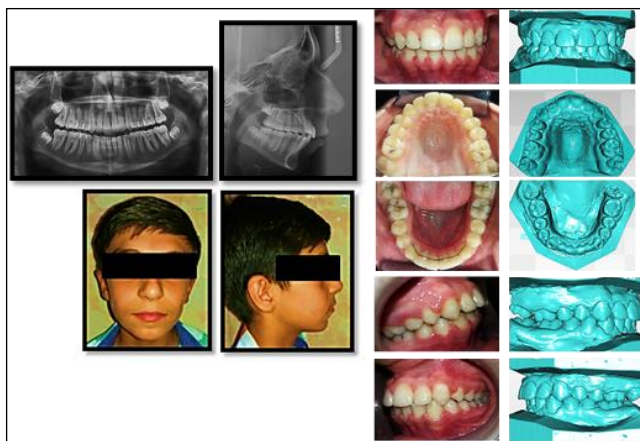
Second patient: post-treatment photographs and radiographs
